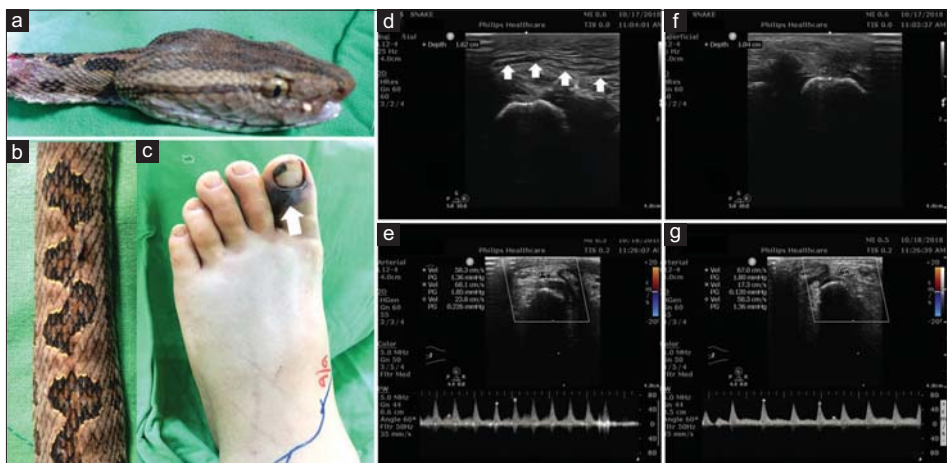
Protobothrops mucrosquamatus* identification and sonography assisted. (a) There is a horizontal brown band of diffuse pigment across middle of eye. (b)The upper body is light brown with mid-dorsal of series chocolate shades. (c) A 30-year-old male, he was bitten over the left big toe (arrow). Ecchymosis presented over the big toe and cyanosis, swelling distended over the dorsal foot. (d-g) The 8-year-old patient was bitten over left medial malleolus with two fang markers (picture not shown). Sonography showed cobblestone sign (arrow) over the subcutaneous area, not in the fascia, with increased depth 1.62 cm (d) compare with the healthy side, 1.04 cm (f). Pulsed Doppler over the dorsalis pedis artery revealed equal blood flow velocity between the lesion site (e) and healthy site (g)
